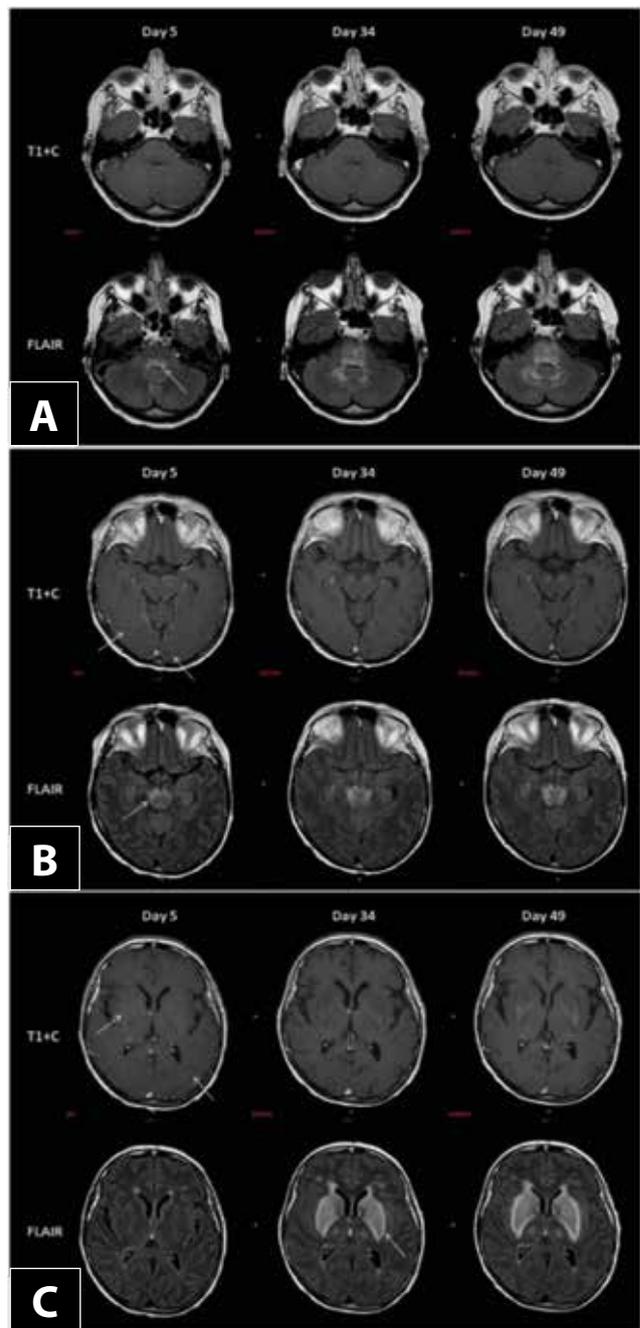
A. Top row: axial T1 with intravenous contrast. Bottom row: axial FLAIR. Arrow bottom row: increased FLAIR signal in brainstem. Progressive FLAIR abnormalities in brainstem and cerebellum on day 34 and day 49
